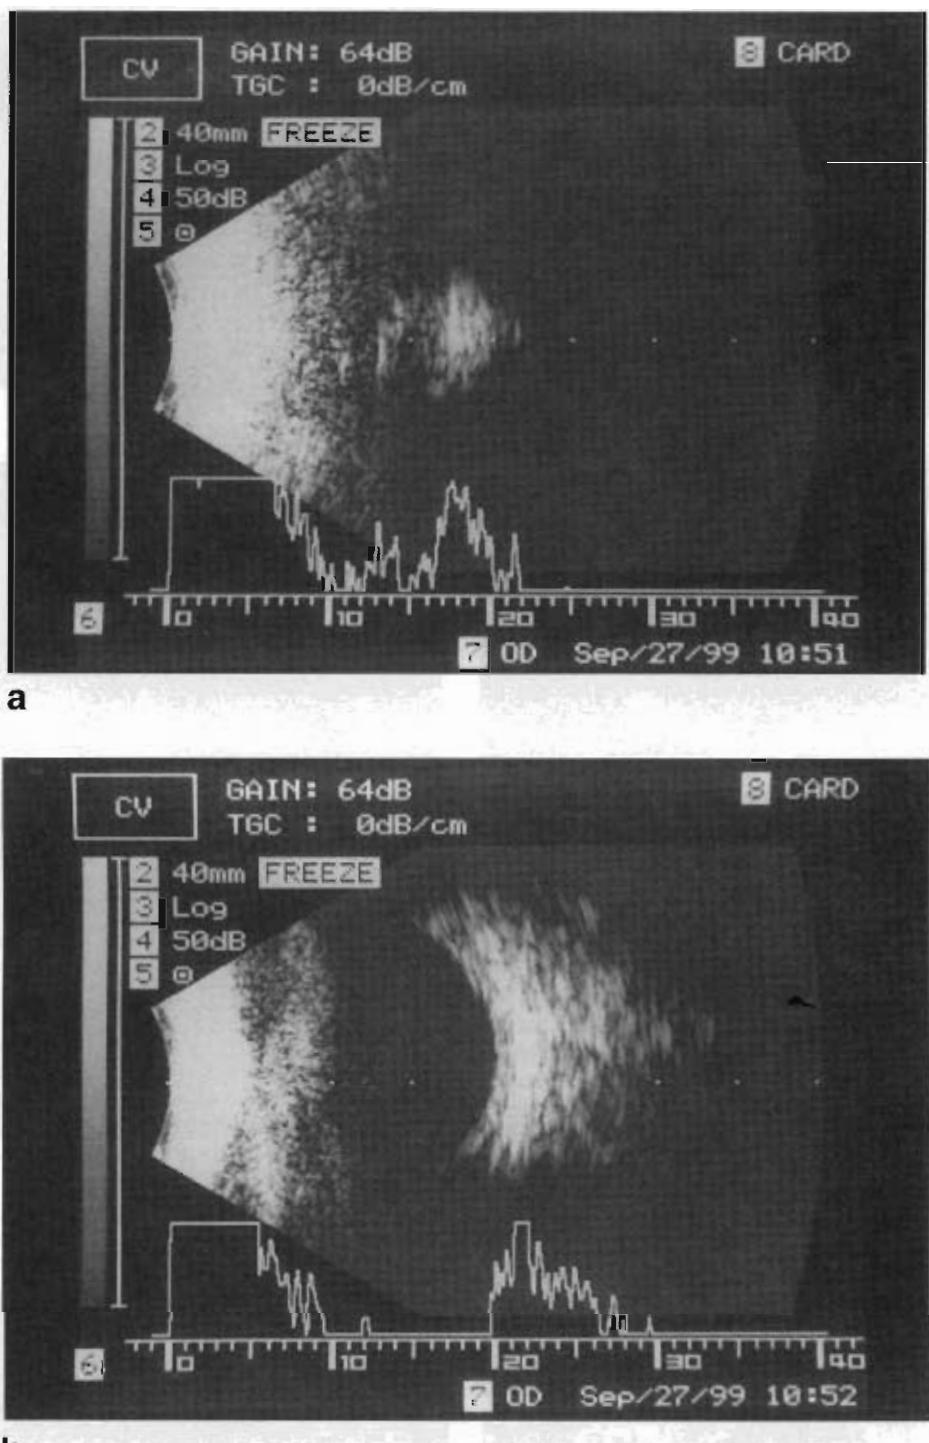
Ultrasonograms. a: A rudimentary globe of the right eye. No compartments or acoustic signal of the anterior segments. Vitreous space is obliterated. b: Microphthalmic globe of the left eye. No details of anterior segment compartments suggestive of fusion of the eyelids with the anterior structures. Note retinal curvature and partially developed vitreous space.
